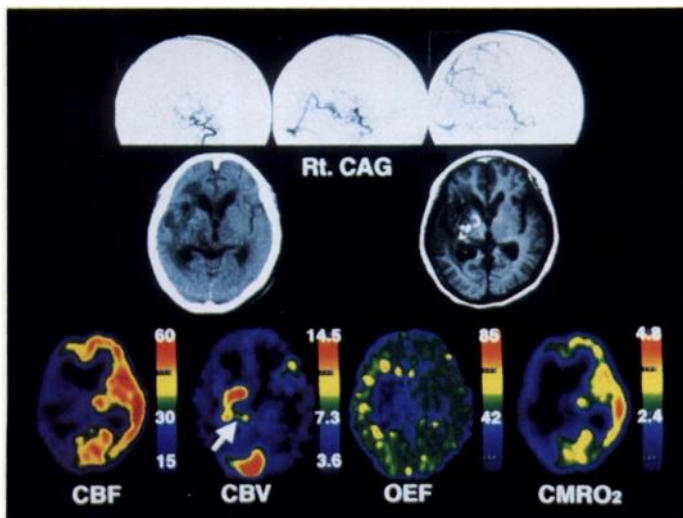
Second PET obtained 2 mo after the initial study (99th hospital day), CAG (top row), CT, MRI (middle row), CBF, CBV, OEF and CMRO₂ images (bottom row). Compared to the first study, total CBF was increased, the CBV in the AVM decreased, total OEF decreased, and CMRO₂ remained unchanged. Arrow points to regressed AVM on the CBV image. Results of arterial gas analysis were pH 7.437, PaCO₂ 40.1 mmHg, PaO₂ 83.1 mmHg, SaO₂ 96.5% and hemoglobin concentration 12.4 g/dl in room air.
